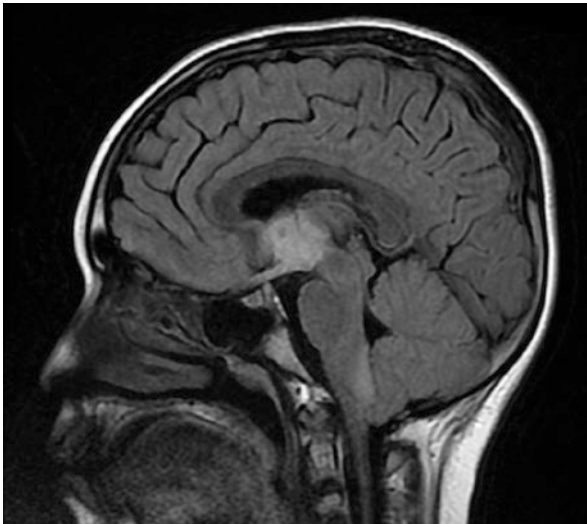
NMO. Sagittal T2 MRI in a 9-year-old female with NMO, demonstrating characteristic involvement of aquaporin 4-rich regions on the brain (e.g. hypothalamus and area postrema of the medulla)
